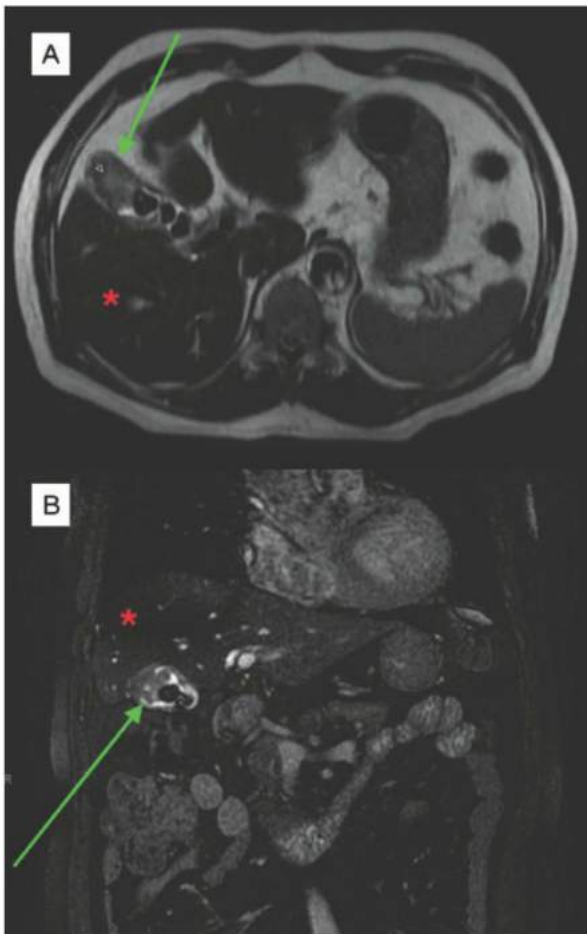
• Axial (A) and coronal (B) contrast-enhanced MRI findings of gallbladder cancer. A focal thickening of the gallbladder wall is noted (green arrows) adjacent to the normal hepatic parenchyma (red asterisks).
